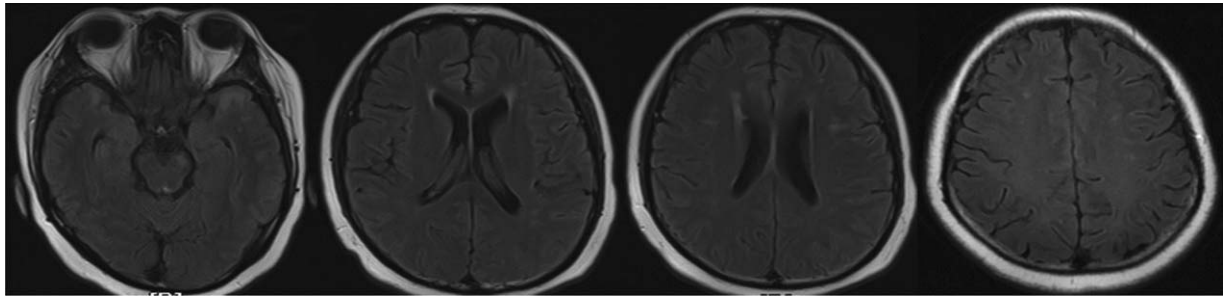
Brain MRI showing T2 lesions in the left cerebellum, bilateral temporal lobe, frontal lobe, lateral ventricles, and center of semioval without Gd enhancement.
